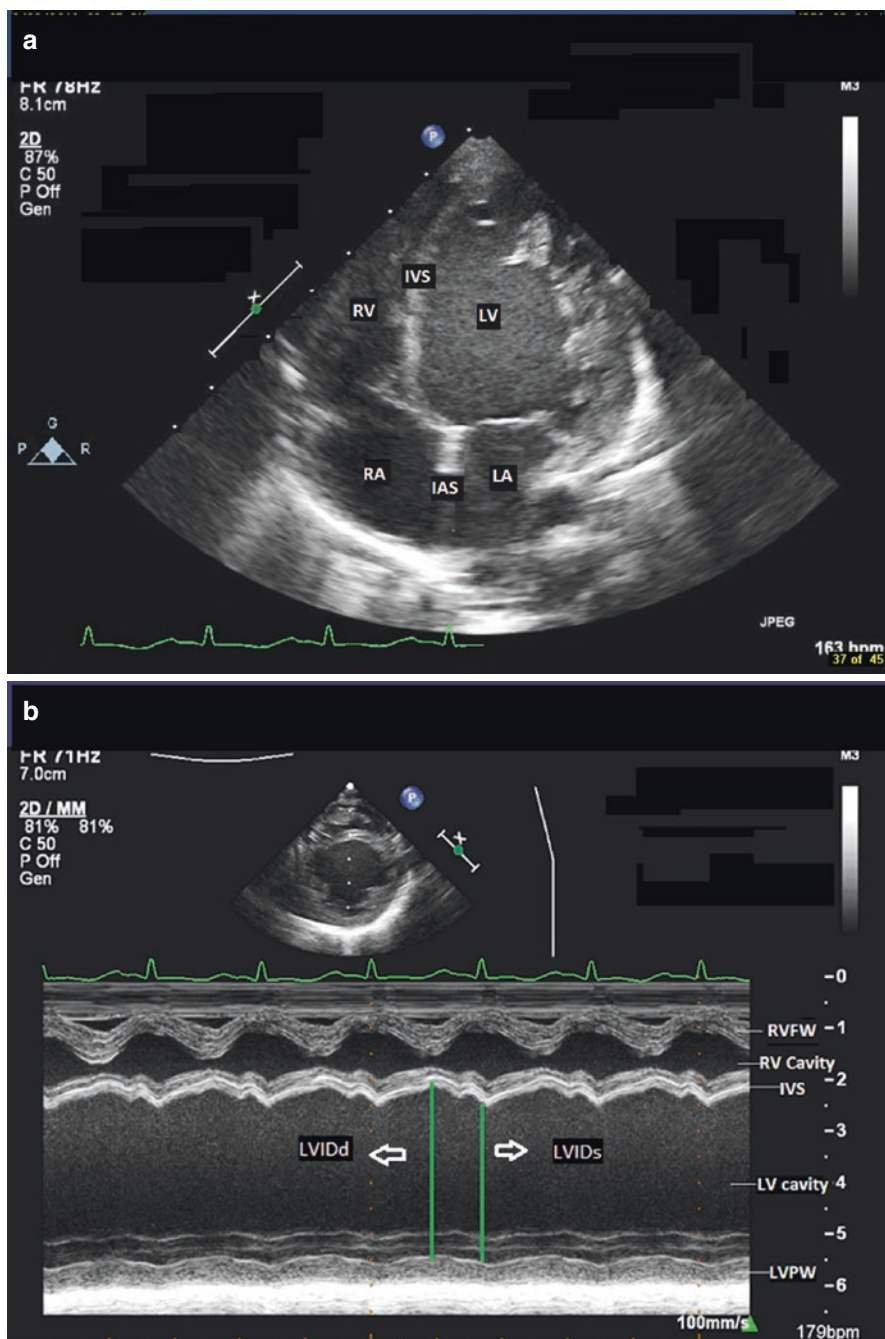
A severely dilated left ventricle with decreased systolic excursion of the ventricular walls in a 6-year-old girl in shock. (a) Apical four-chamber view (b) parasternal short-axis view, as seen in M-mode echocardiography. The left ventricle is dilated; the ventricular walls show minimal contraction during systole, so function is severely decreased. RA right atrium, RV right ventricle, IAS interatrial septum, IVS interventricular septum, LA left atrium, LV left ventricle, RVPW right ventricular free wall, RV cavity right ventricular cavity, LVPW left ventricular posterior wall
